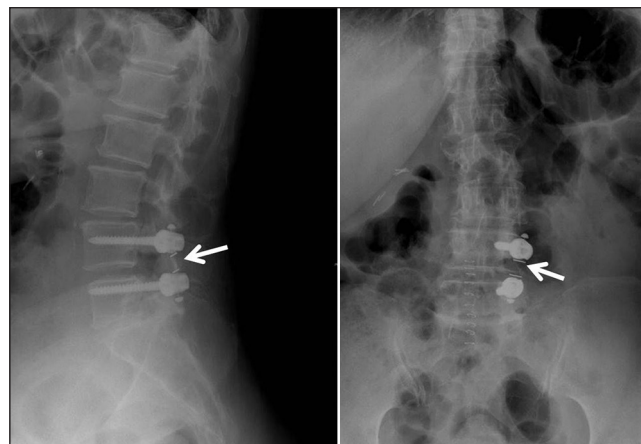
Lateral and posterior-anterior radiographs show the screws and BalanC rod system replacing the left facet joint at L3-4
